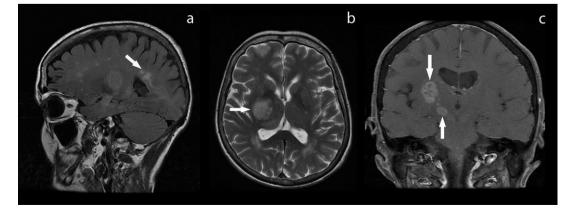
(a) Sagittal fluid attenuated inversion recovery (FLAIR) MRI showing a large mass in the right lentiform nucleus with multiple hyperintense foci in the parieto-occipital and parieto-frontal regions (arrow); axial T2-weighted (b) and coronal T1-weighted contrast enhanced (c) MRI displaying enhancing lesions in the lentiform and thalamic nuclei (arrows).
